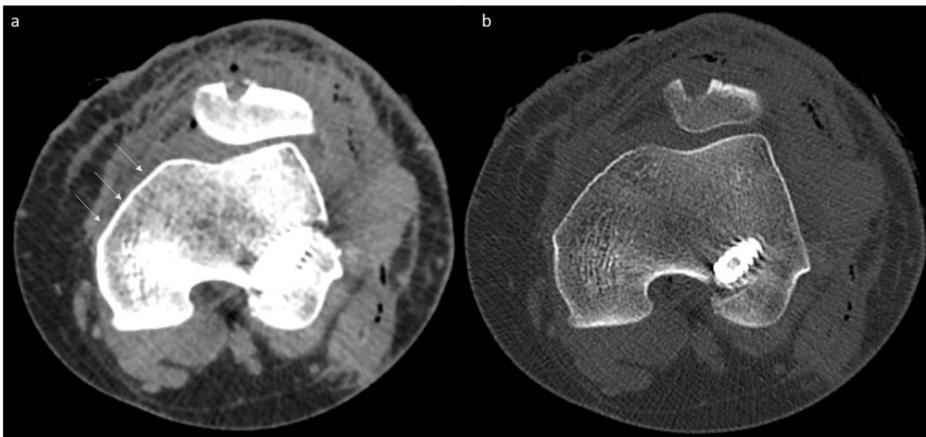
a CT images soft tissue image and bone image of the same slice in the same knee. Note the slightly blurred bone cortex on soft tissue image (arrows), and the lack of soft tissue detail on bone image (image b).
